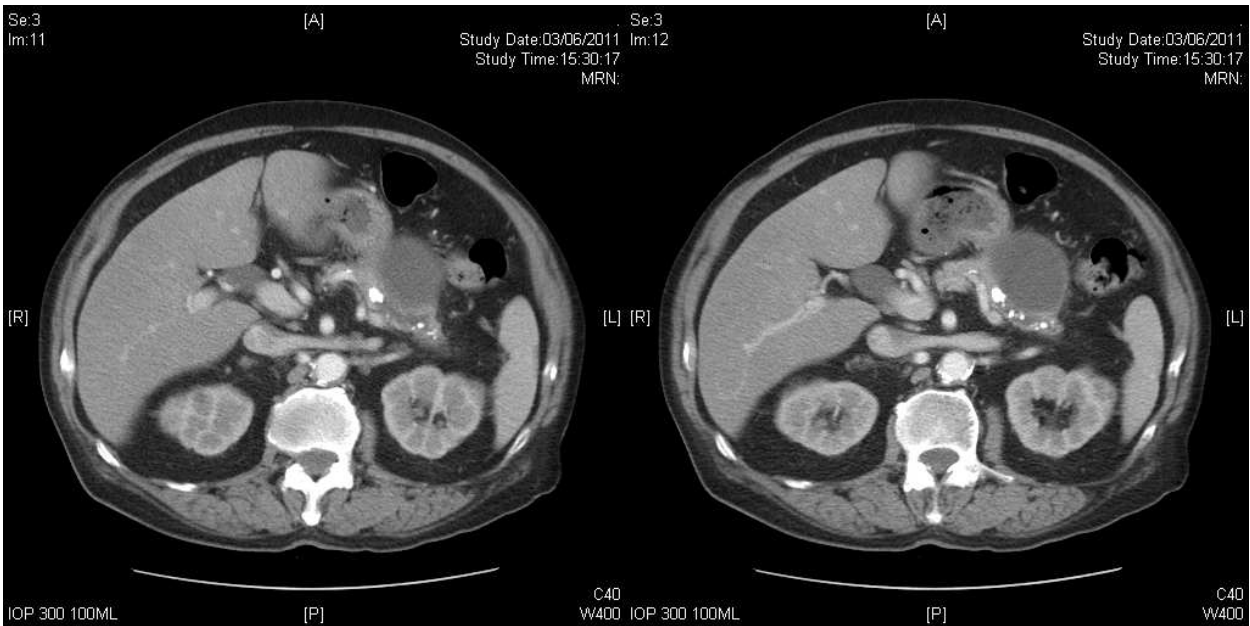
Computed tomography showing pseudocyst near the tail of pancreas with mild pancreatic duct dilatation and stones proximal to the cyst.
